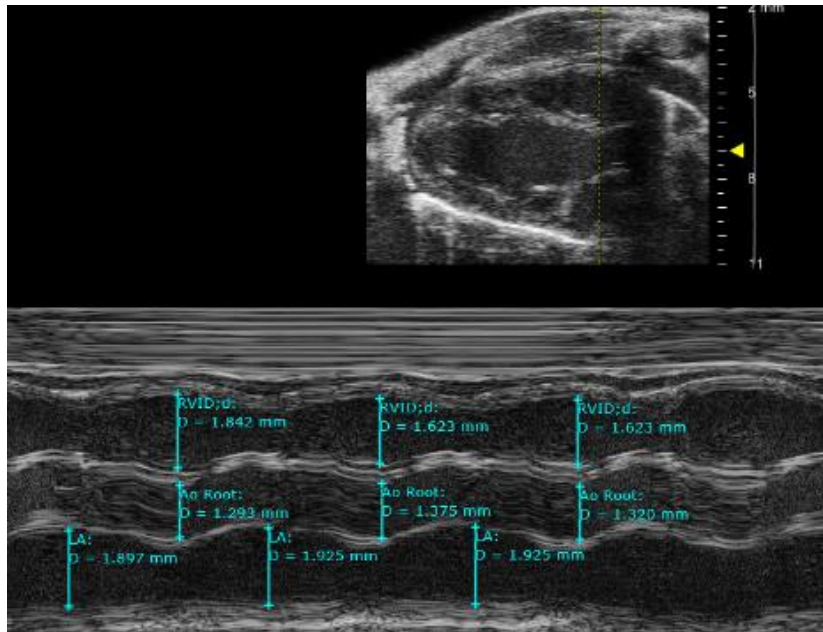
M-mode of Parasternal long-axis view, at the aortic root level.
